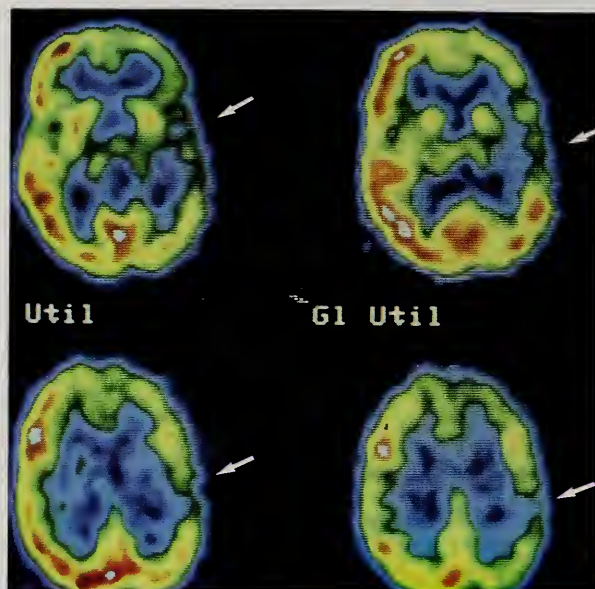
This patient with a temporal lobe focus and right temporal hypometabolism on the FDG-PET scan also demonstrated remote suppression of cerebral metabolism, with decreased glucose metabolism in the high right frontal and parietal regions (arrows).
